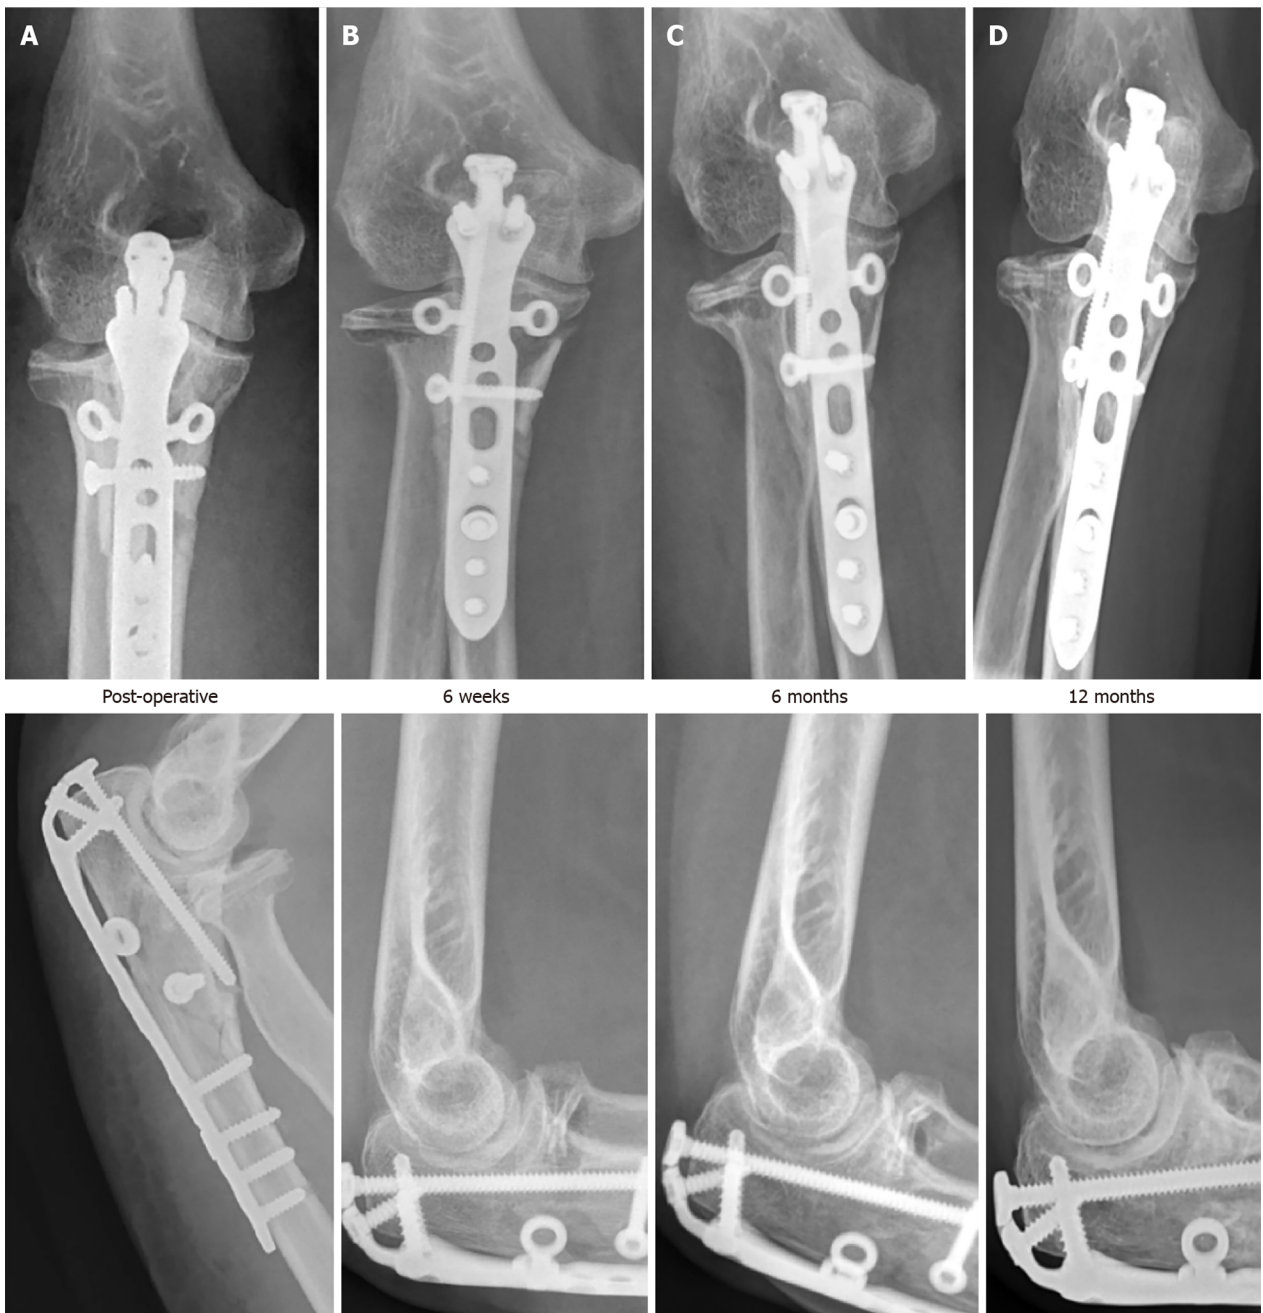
Post operative radiographs depicting progress. A-D: Radiographs immediately post op (A), at 6 wk (B), 6 months (C) and 12 months (D).
